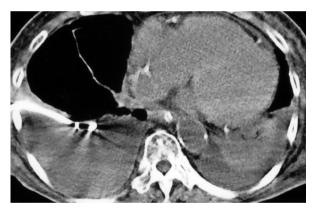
Chest computed tomography revealed massive pleural effusion with subsegmental atelectasis of the LLL; a pigtail catheter was inserted
